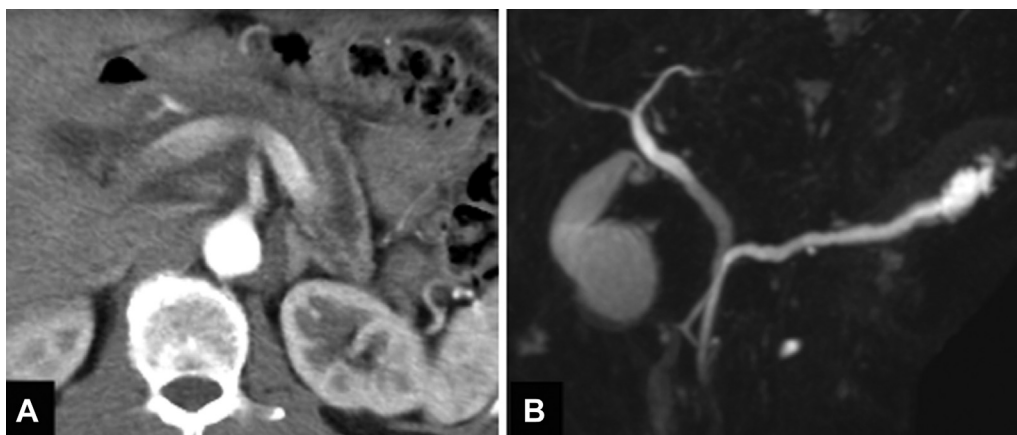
A, Contrast-enhanced CT revealed acute pancreatitis at first visit. B, MRCP showed main pancreatic duct dilation from the head to tail, with cystic dilation in the tail of pancreas.
